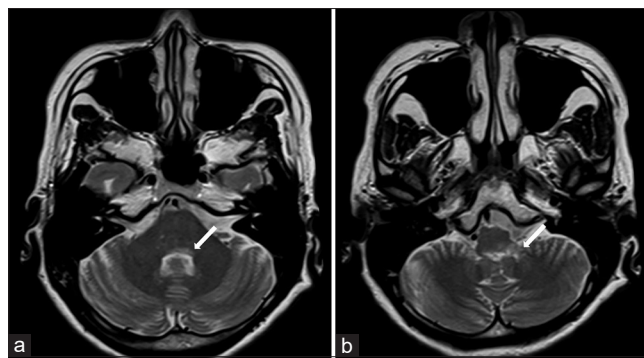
T2-weighted image of the magnetic resonance imaging showing abnormal signal changes at, (a) the left caudal portion of the pons (arrowed) and (b) the dorsal medulla and left cerebellar peduncle (arrowed)
